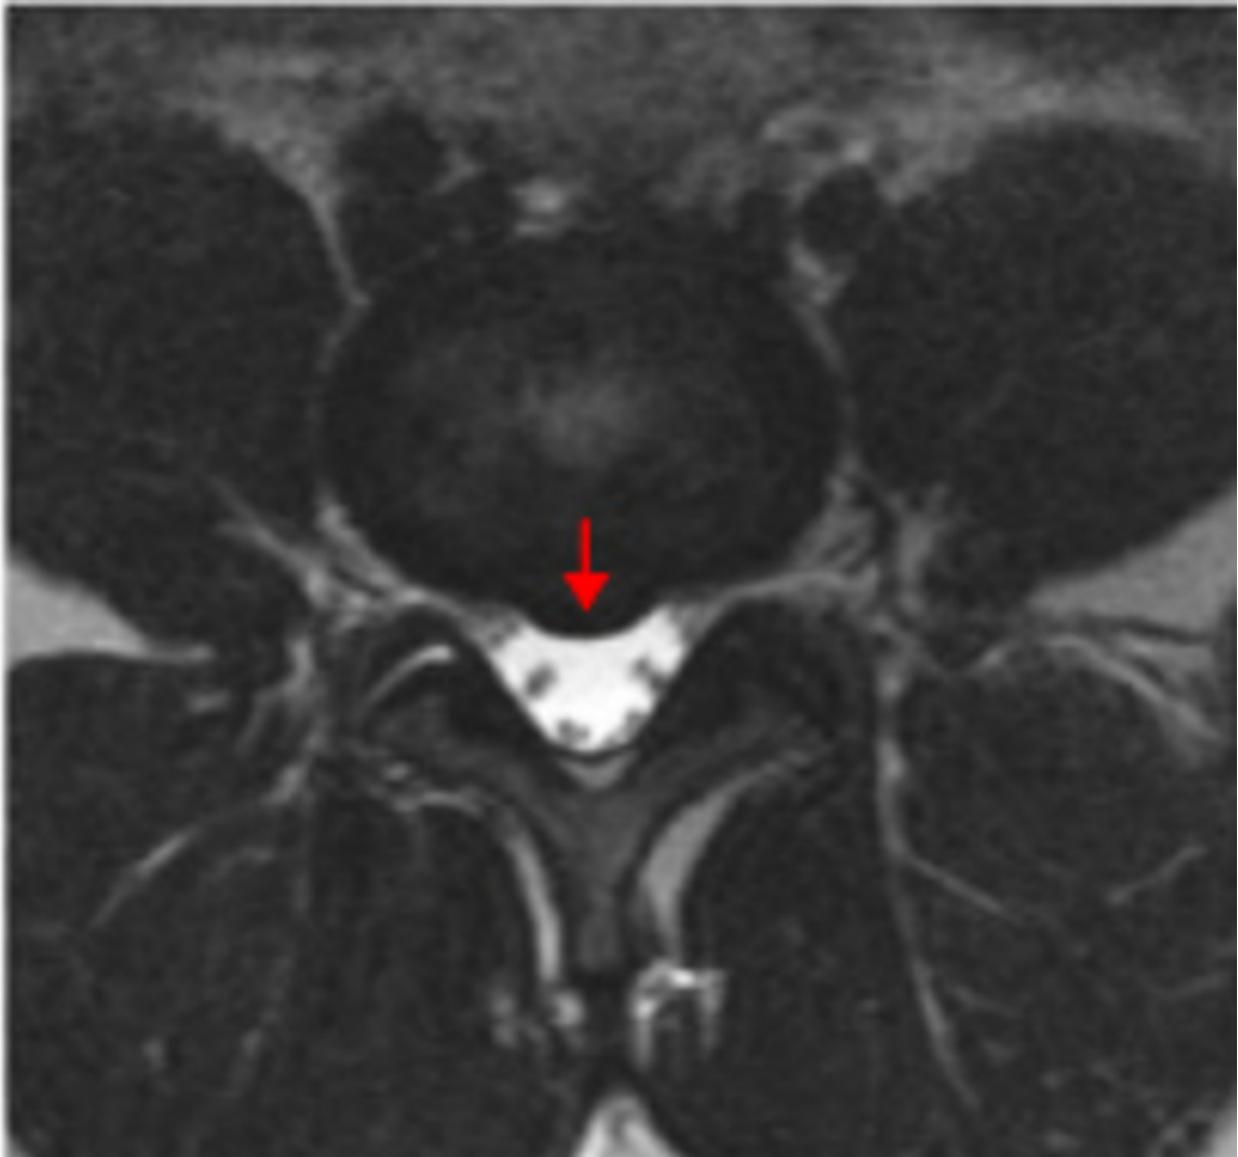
Axial T2 Weighted Lumbar Spine MRI image showing L4/L5 Focal Posterior Central Disc Herniation - Protrusion
